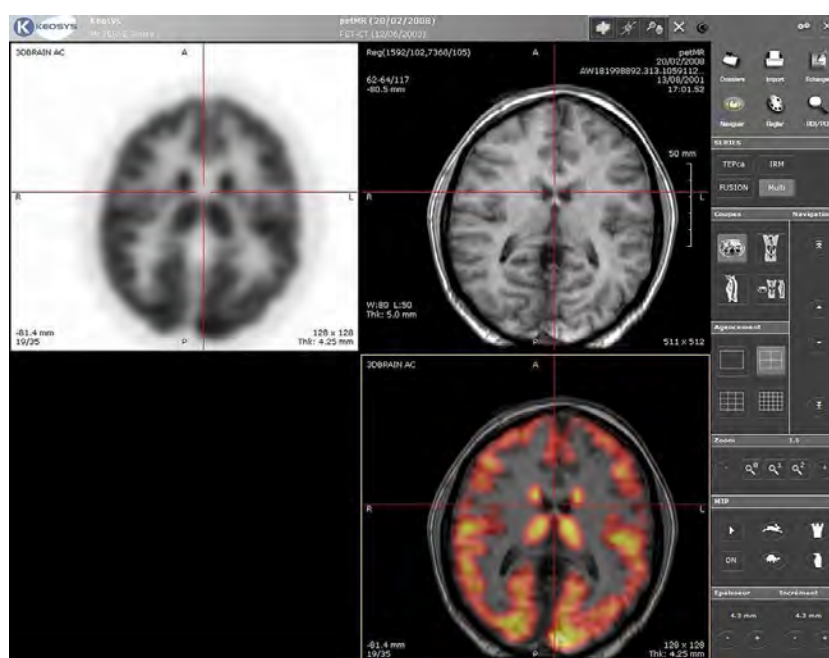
A cohort of axial brain MRI images
